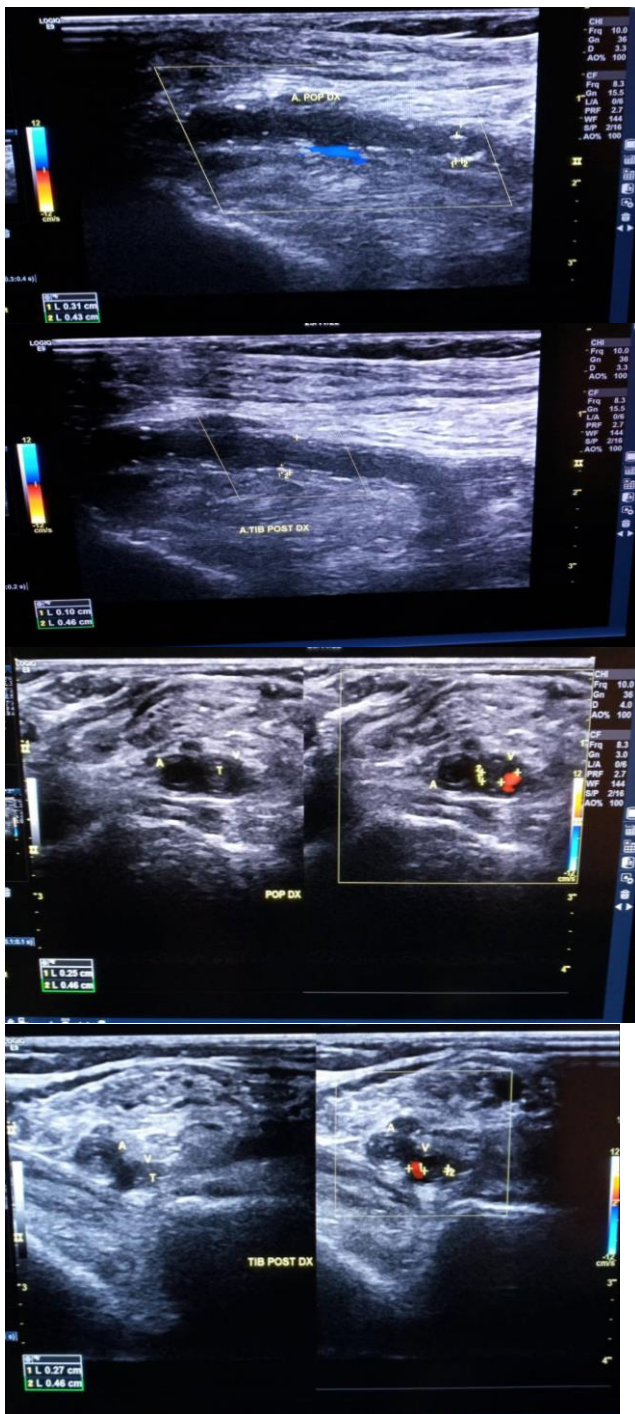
Doppler ultrasound.
